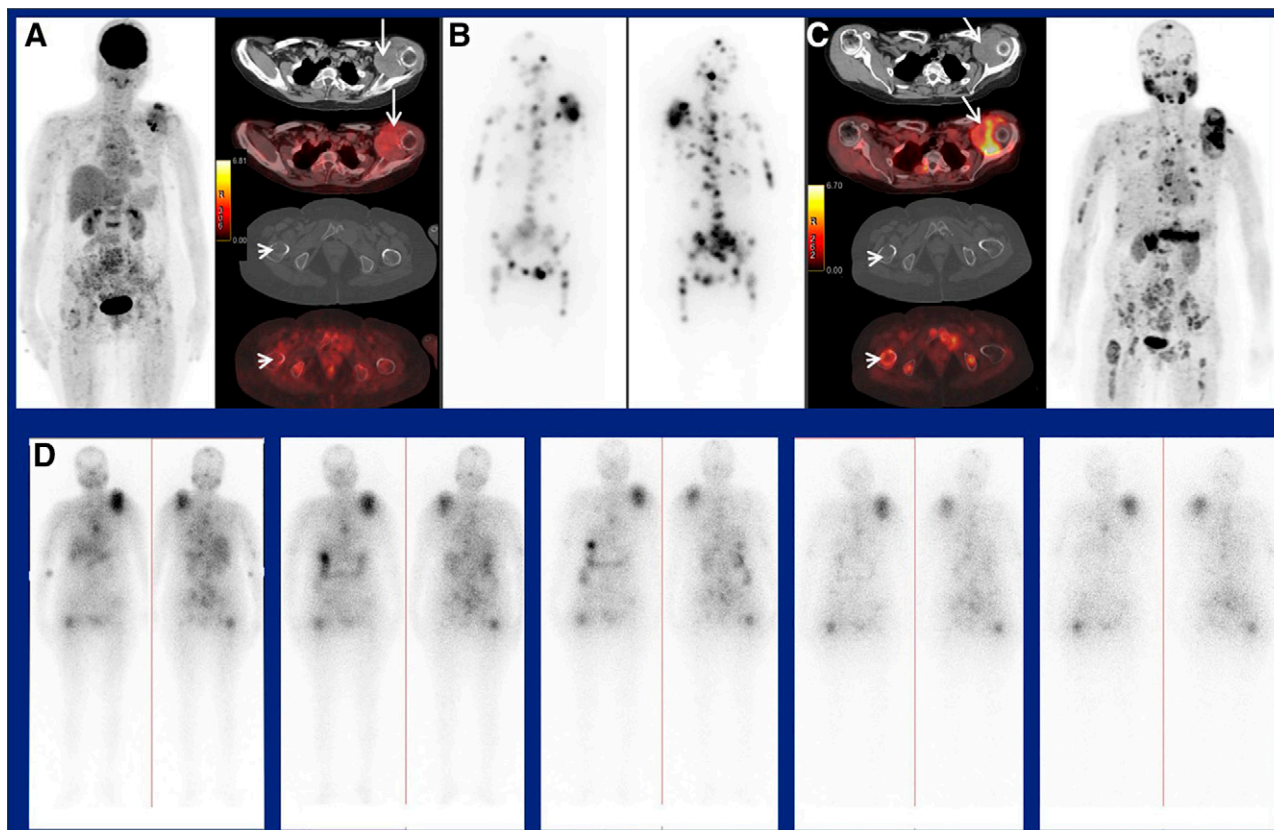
^{177}Lu -DOTAGA (SA FAPI) $_2$ therapy as a salvage treatment option in end-stage differentiated thyroid cancer. A. Pretreatment ^{18}F -FDG PET/CT. B. Post- ^{131}I therapy whole-body scans. C. ^{68}Ga -DOTA (SA FAPI) PET/CT. D. ^{177}Lu -DOTAGA (SA FAPI) $_2$ serial whole-body PET acquired at 1, 24, 48, 96, and 168 h after treatment. Rapid accumulation of radiotracer is seen in the 2-h image with long retention.
